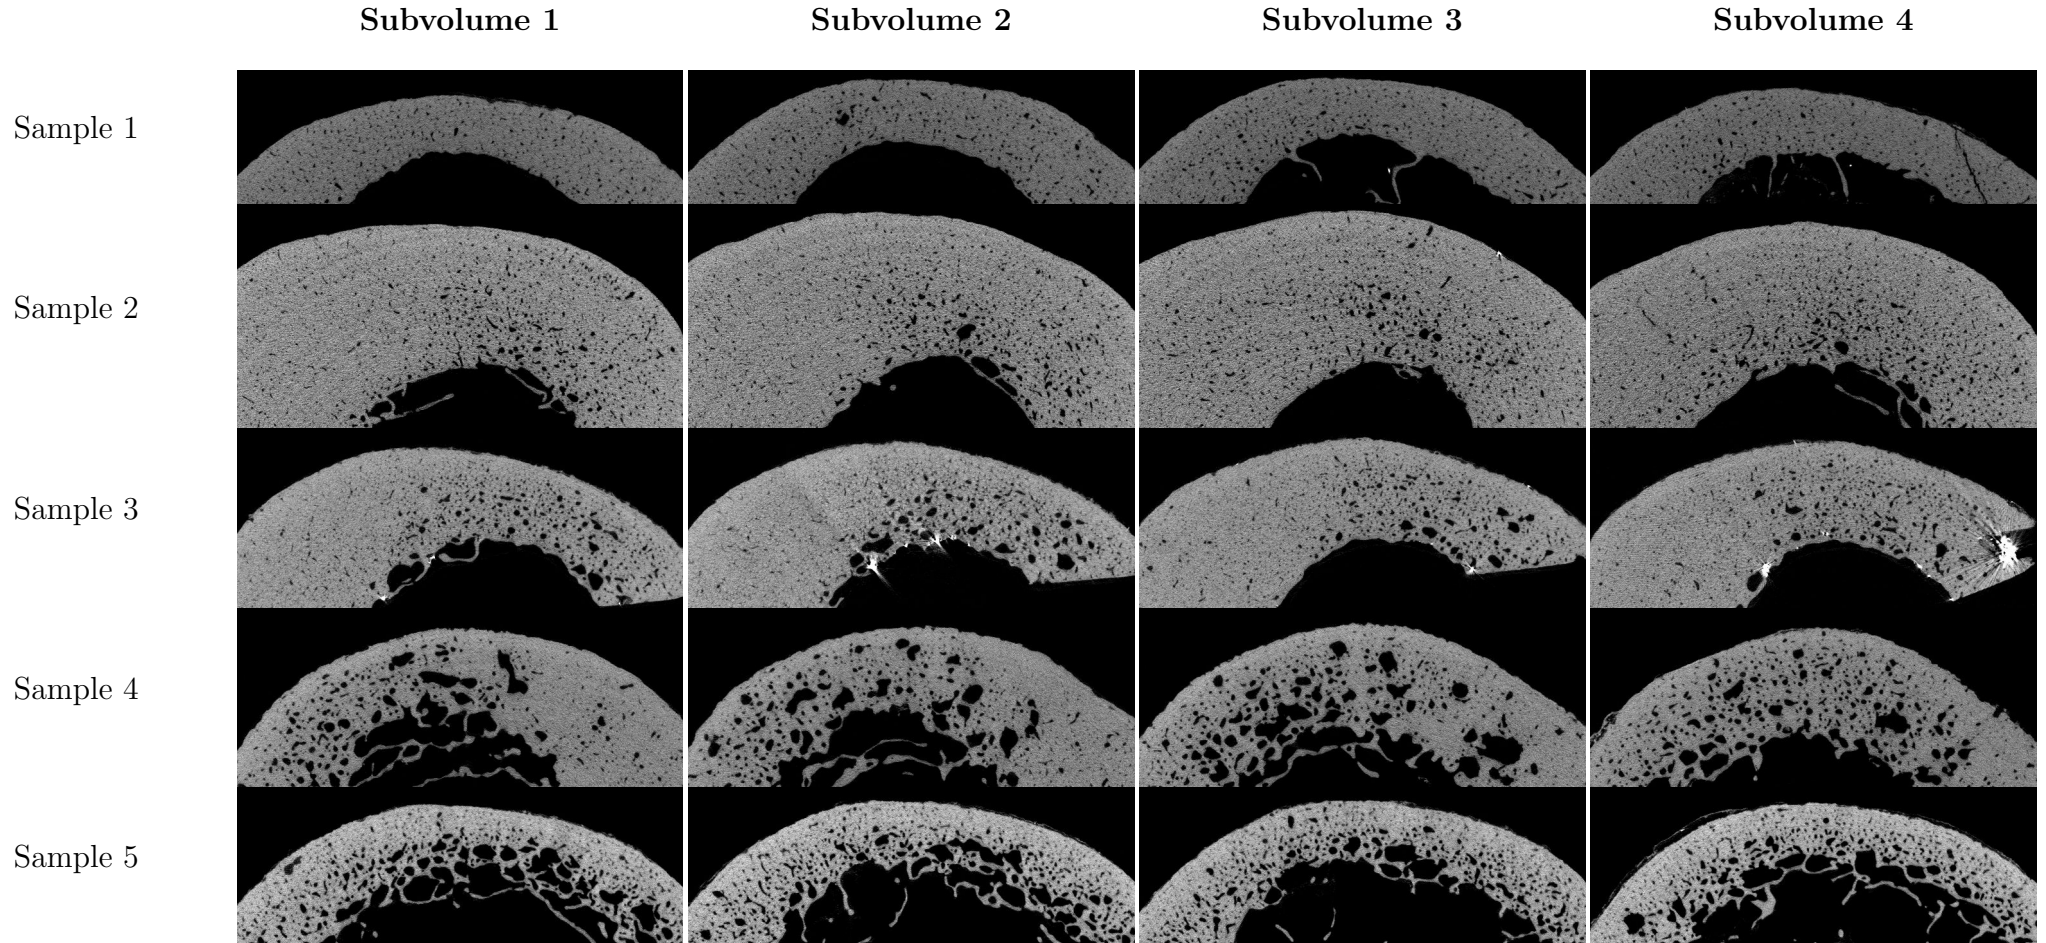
Reference X-ray images of all samples. An example slice is shown for each subvolume.
